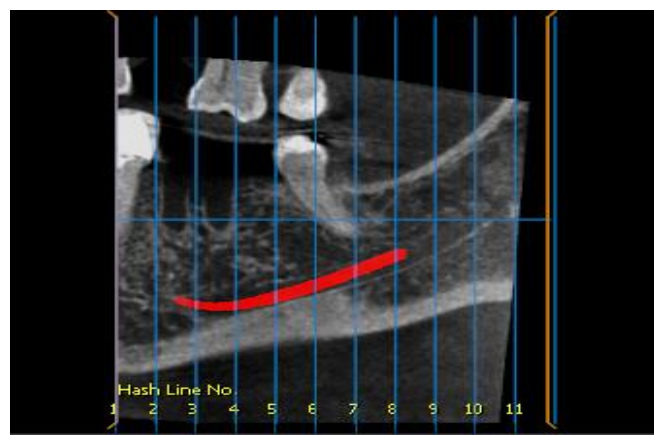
Panorama CBCT image showing the studied sections with 5 mm intervals
